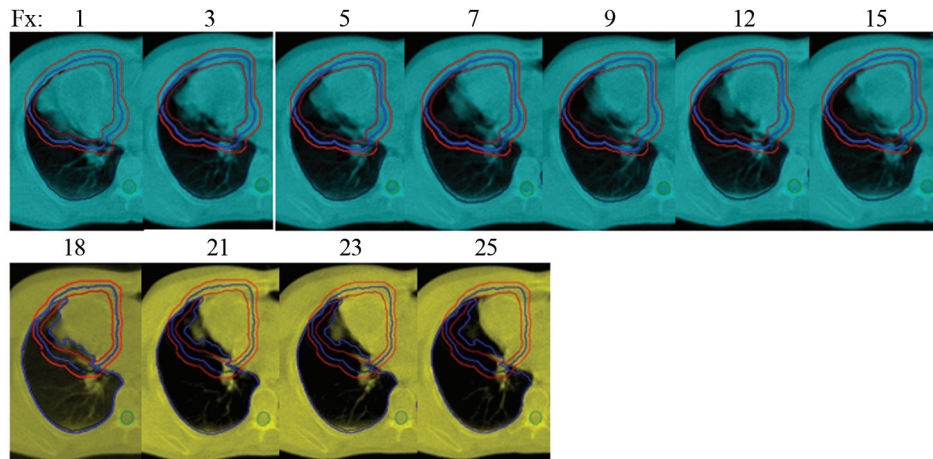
Megavoltage computed tomography (MVCT) scans at the time of specific fraction (fx) delivery. The contours in the top row show the initial internal target volume (ITV), clinical target volume (CTV), and planning target volume (PTV). Those in the second row show the new ITV, CTV, and PTV.
